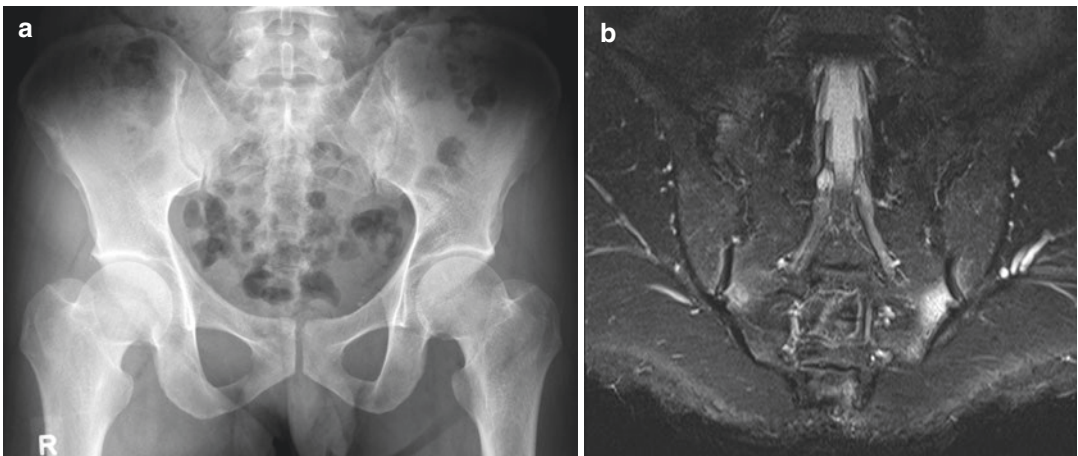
A 35-year-old man who presented with worsening back pain, on a background of chronic back and polyarticular pain. (a) Frontal radiograph of the pelvis shows no significant abnormality. (b) Coronal TIRM MR image of the sacrum shows periarticular marrow edema involving the inferior aspect of both sacroiliac joints
